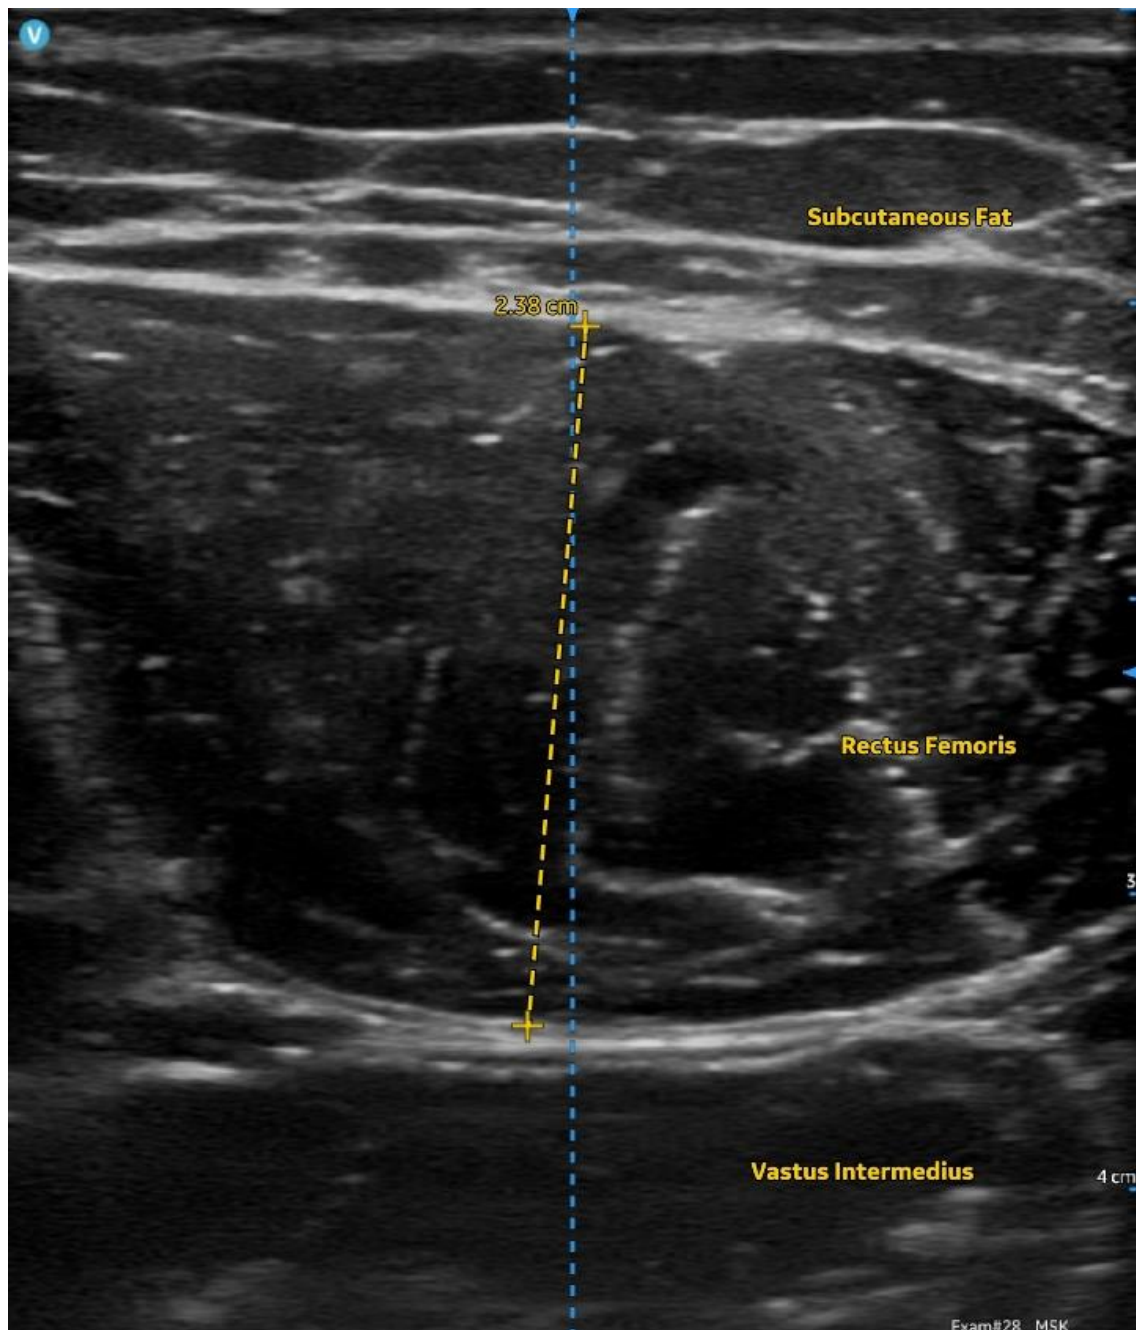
Example of ultrasound measurement of Rectus Femoris muscle thickness (RFMT) in the transverse plane.
